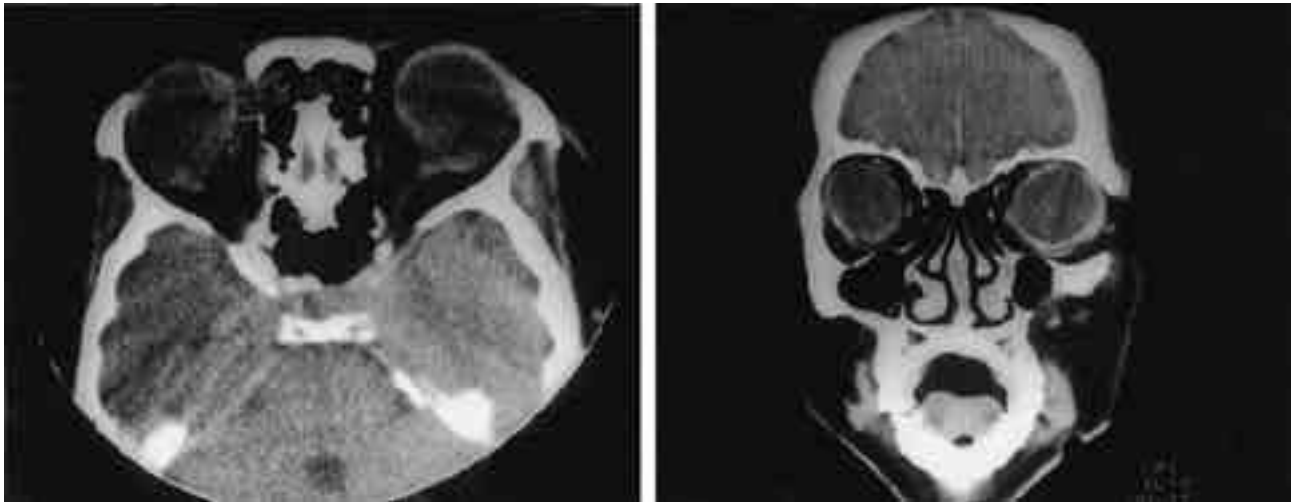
Computed tomography scans of the orbits demonstrating marked oval enlargement of the globes, nearly filling the orbits and normal cross-sectional appearance of extra-ocular muscle. Left: Coronal view, Right: Axial view.
